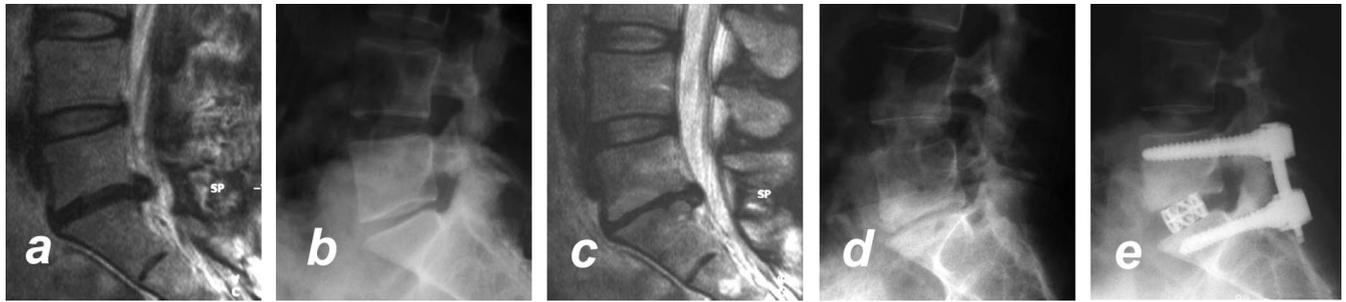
a-e, MRI and radiograph of a 32-year-old female with re prolapse L5/S1 and initial disc degeneration (MODIC I) accompanied by a new neurological deficit (a, b). The patient presented with progredient disc degeneration (MODIC II) at follow-up examination (c, d). Consecutively, a ventro-dorsal spondylodesis was performed.
